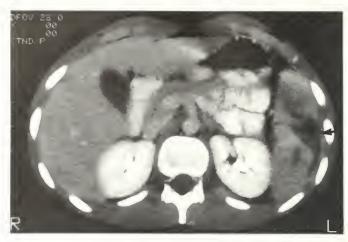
CT scan demonstrating splenic fracture in a 14-year-old girl injured in a soccer game.
